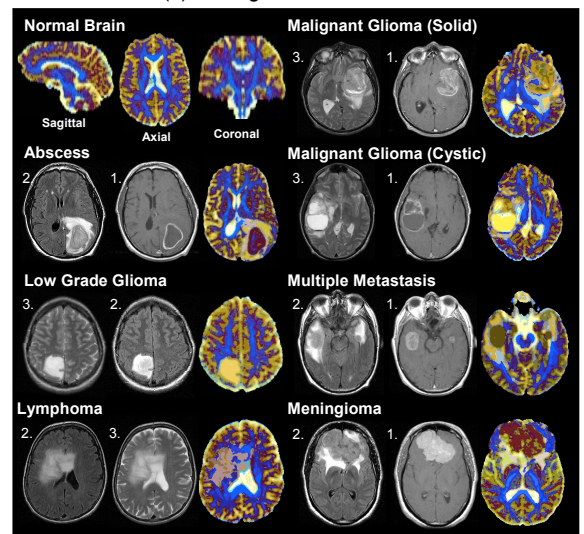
DCM maps created by application to variety of intracranial pathology. (1) T1+Gd, (2) FLAIR, (3) T2.
